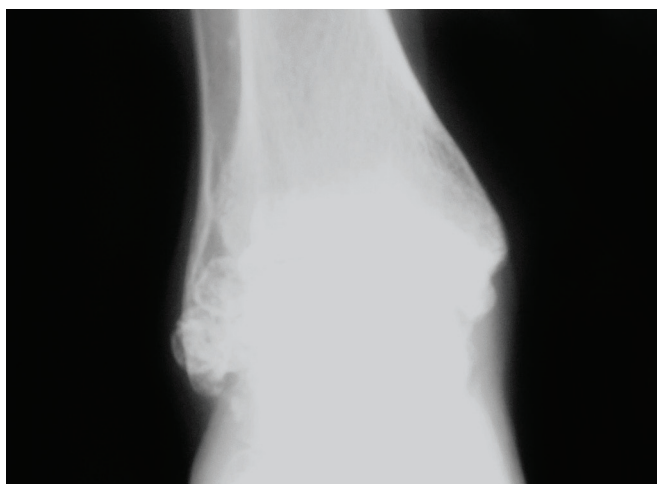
Pre-op X-ray anteroposterior view
